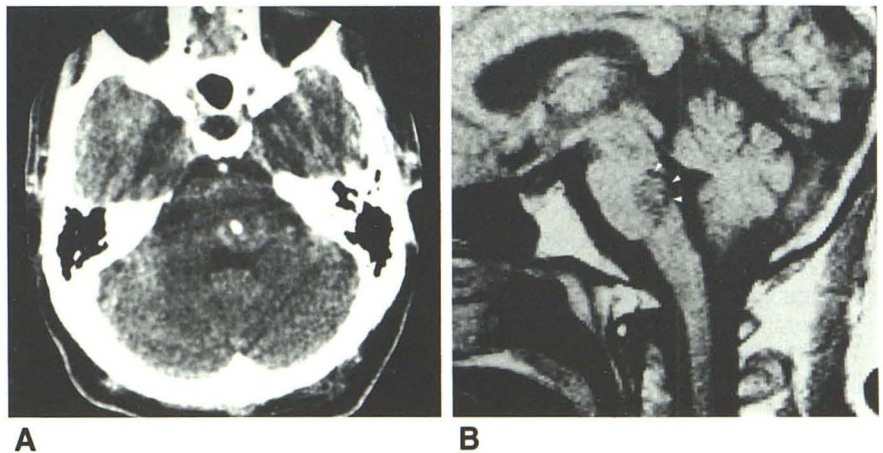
A, Unenhanced CT scan. Slight enlargement of left brachium pontis, with compression of fourth ventricle. Areas of increased attenuation had values of calcium. B, Sagittal SE 30/500 scan. Area of decreased signal surrounded by rim of low signal (*arrowheads*). Vascular malformation (negative angiogram).
